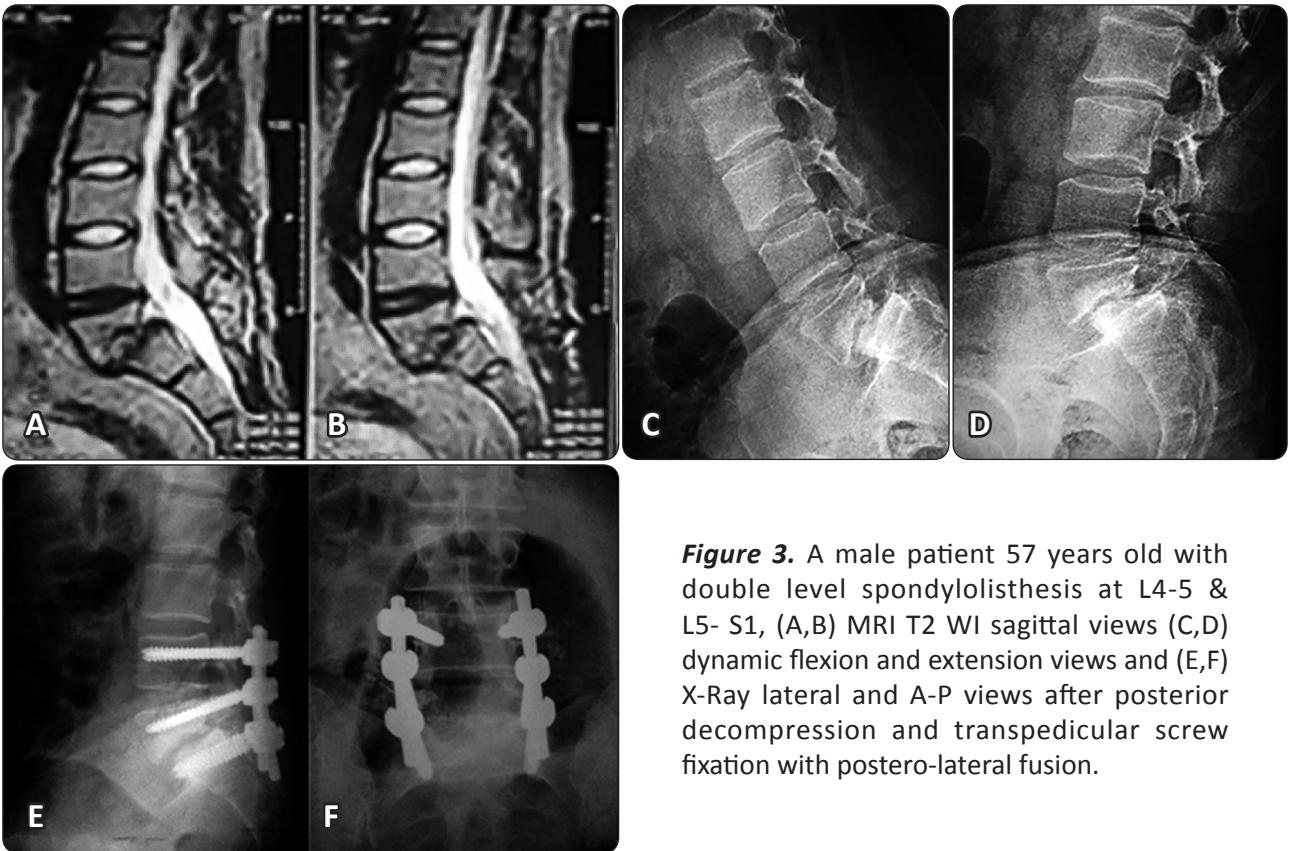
A male patient 57 years old with double level spondylolisthesis at L4-5 & L5- S1, (A,B) MRI T2 WI sagittal views (C,D) dynamic flexion and extension views and (E,F) X-Ray lateral and A-P views after posterior decompression and transpedicular screw fixation with posterolateral fusion.
